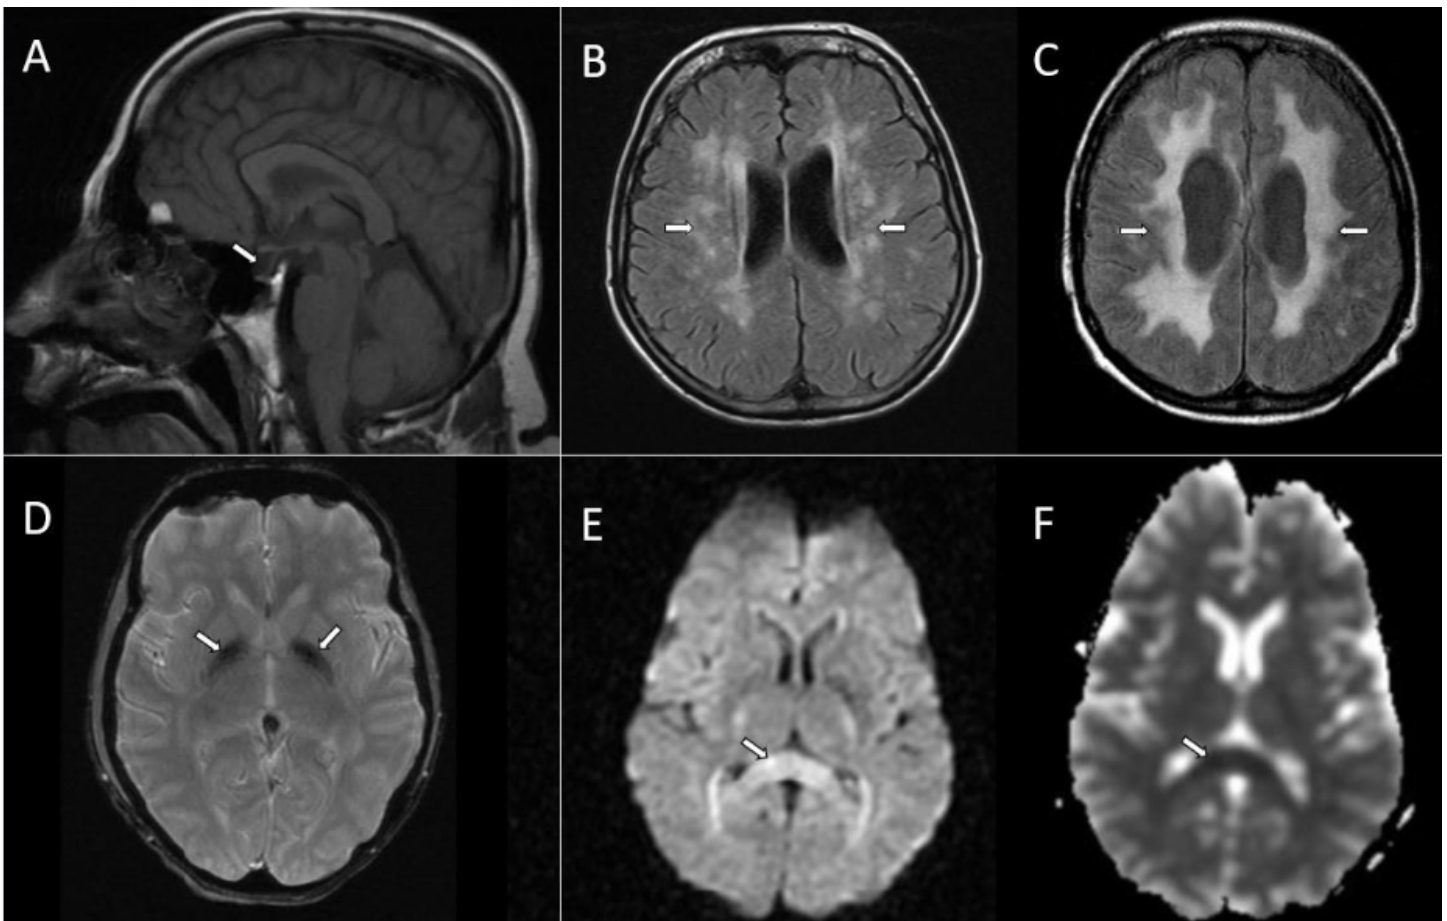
Brain MRI of individuals with WSS. Arrows indicate the following findings:
